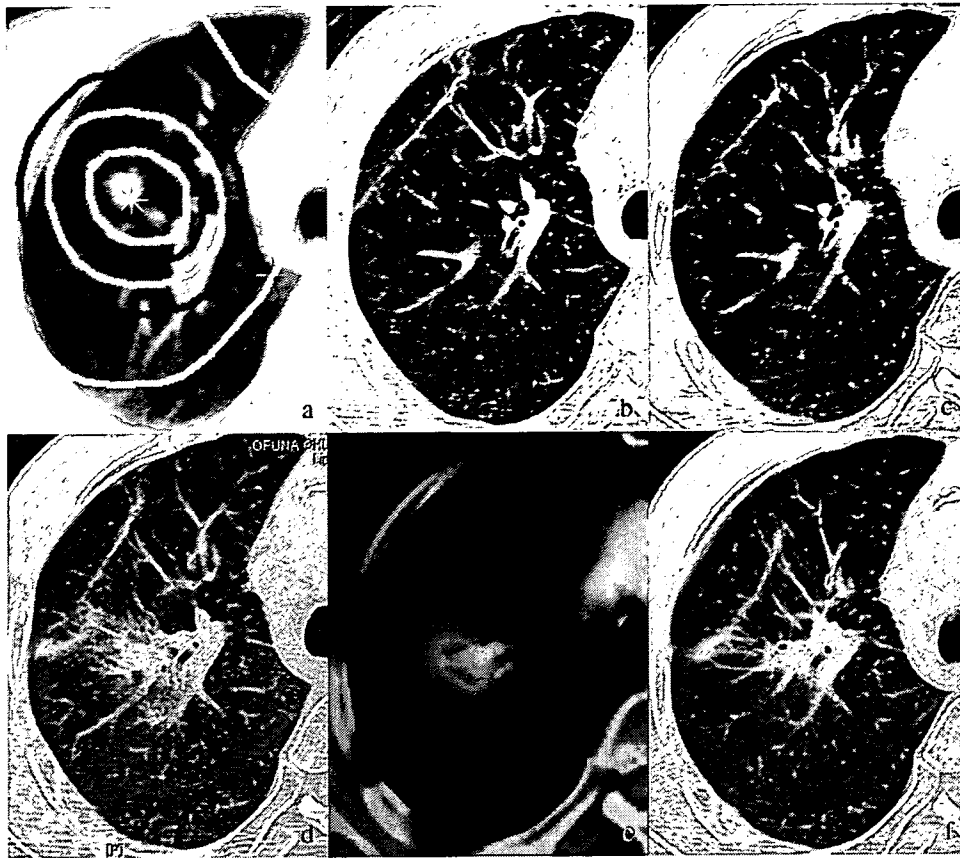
Transverse computed tomography (CT) images and a positron emission tomography (PET)-CT image after hypofractionated stereotactic radiotherapy (HSRT) in an 83-year-old man with adenocarcinoma of the right upper lobe. (a) Pre-HSRT image with dose isodose lines. The red line is the 80% isodose curve and corresponds to planning target volume (PTV). (b–f) Transverse CT images obtained at 19, 22, and 25 months; PET-CT image at 26 months; and transverse CT images at 34 months after completion of HSRT. The solid opacity had enlarged at 25 months after completion of HSRT. Thus, PET-CT was performed to rule out recurrence in the PTV vicinity and showed increased activity (maximum standard uptake value, 3.13) corresponding to the opacity. The solid opacity observed was indicative of local recurrence. However, it diminished 34 months after completion of HSRT.
